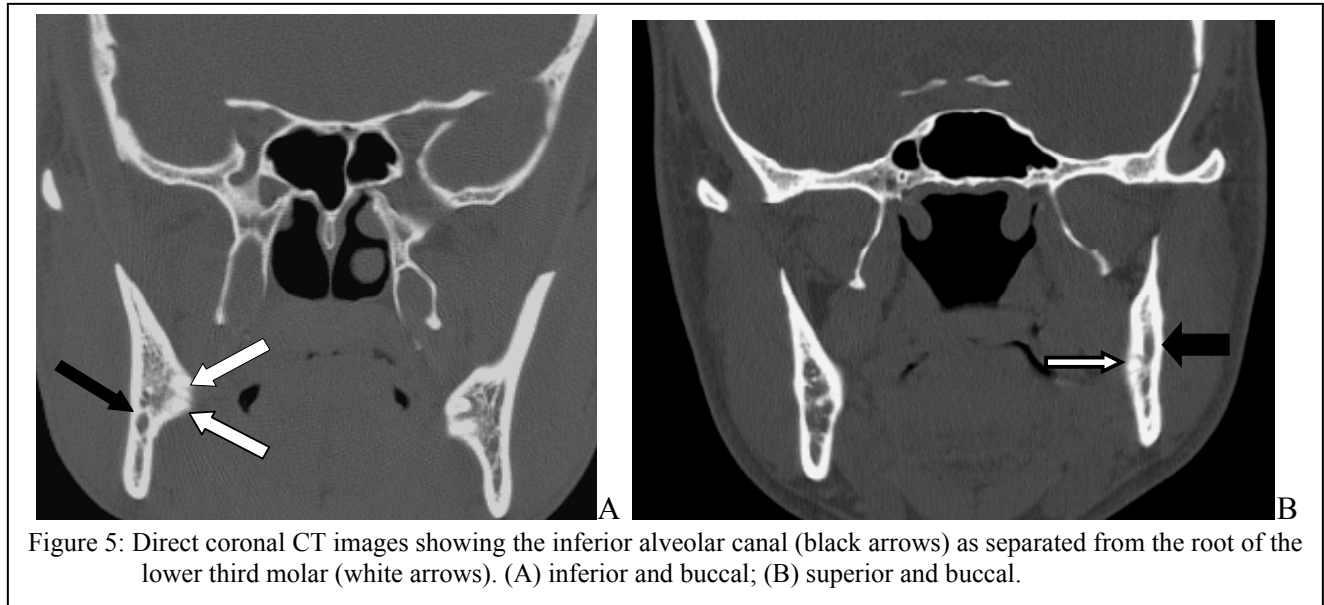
Direct coronal CT images showing the inferior alveolar canal (black arrows) as separated from the root of the lower third molar (white arrows). (A) inferior and buccal; (B) superior and buccal.
